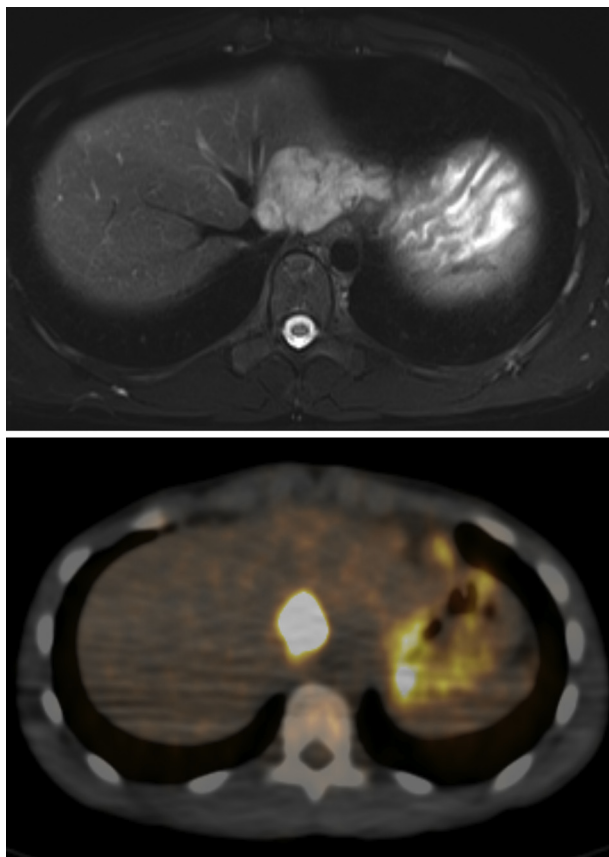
Magnetic resonance imaging and ^{18}F fludeoxyglucose positron emission tomography-computed tomography findings demonstrating invasion into the inferior vena cava.
